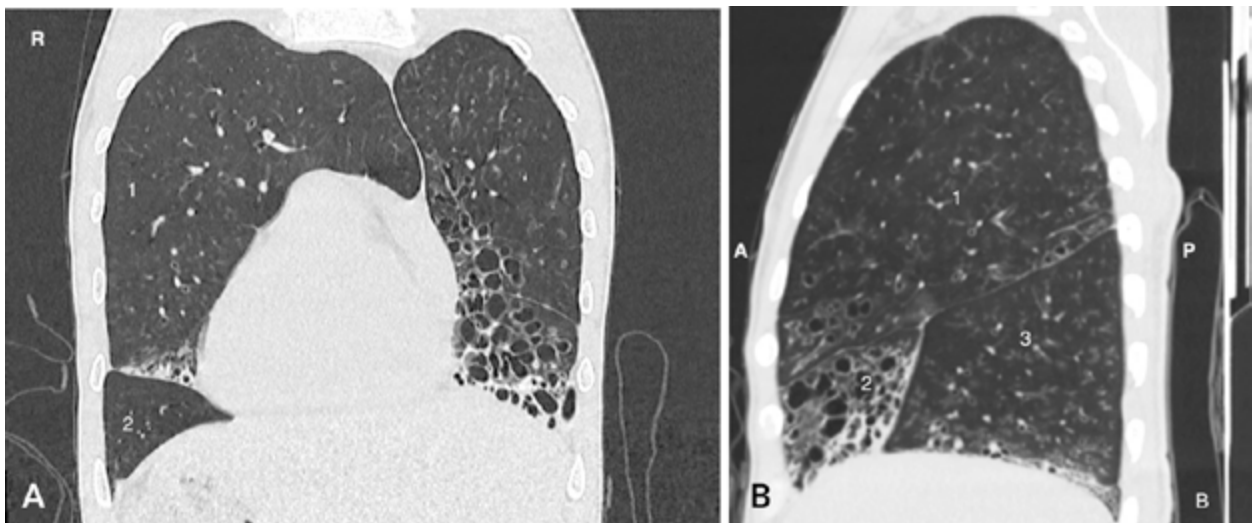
High-resolution computed tomography of the chest with isomerism of the bronchial branching pattern. A) coronal view of bi-lobed right lung; B) sagittal view of tri-lobed left lung.
